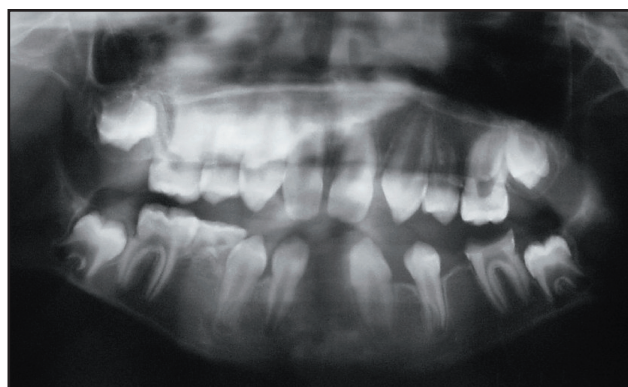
Panoramic radiograph revealed the patient's oligodontia, root abnormalities, and taurodontism in all her premolar teeth.
